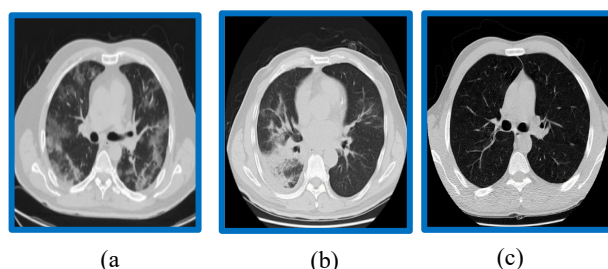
Examples of CT-Scan images include those for (a) COVID-19 (b) pneumonia and (c) normal.
